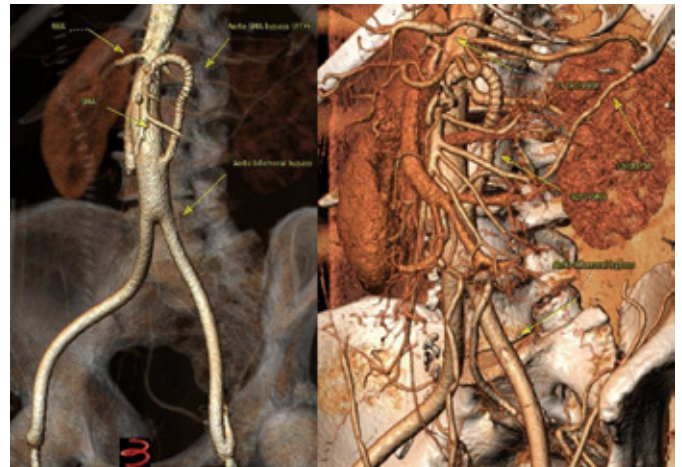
Follow-up CTA revealed patency of both bypasses; aorto-bifemoral and aorto-SMA. An S configuration was used for the SMA bypass to avoid kinking and occlusion. Important collaterals between the SMA and the CT preserve flow in the rest of the splanchnic organs.
